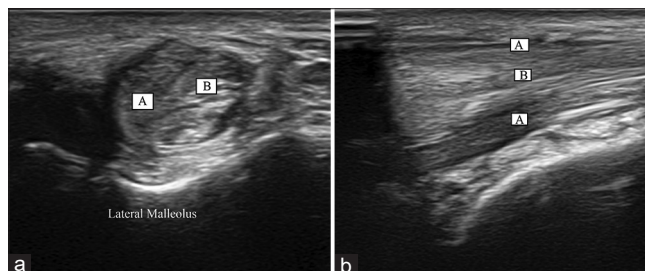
Short-axis (a) and long-axis (b) ultrasound images of the lateral retromalleolar region of the ankle are shown. Identify the structures marked as “A” and “B”
